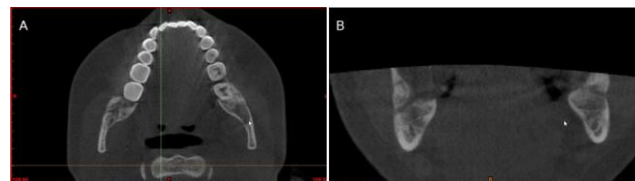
A), B) CBCTs; A) axial and B) coronal cuts 6 months postoperative showing normal bone healing
